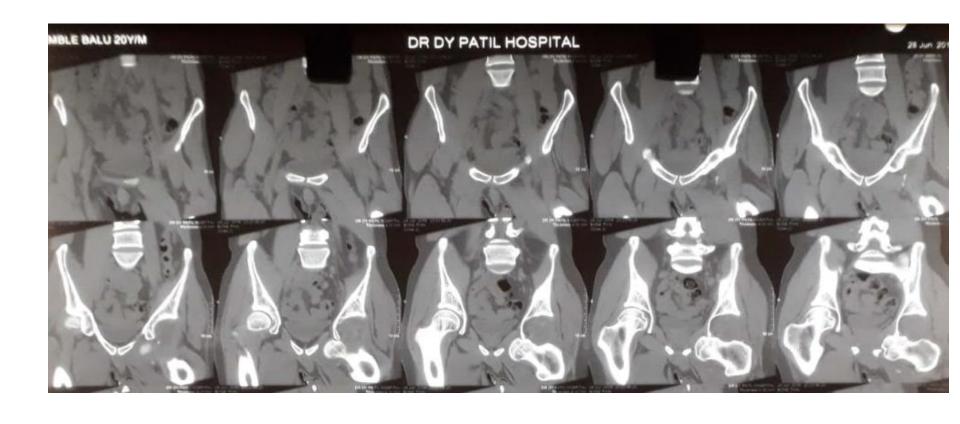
PRE OPERATIVE X-RAY OF THE PATIENT SHOWING INFERIOR DISLOCATION OF THE HIP
